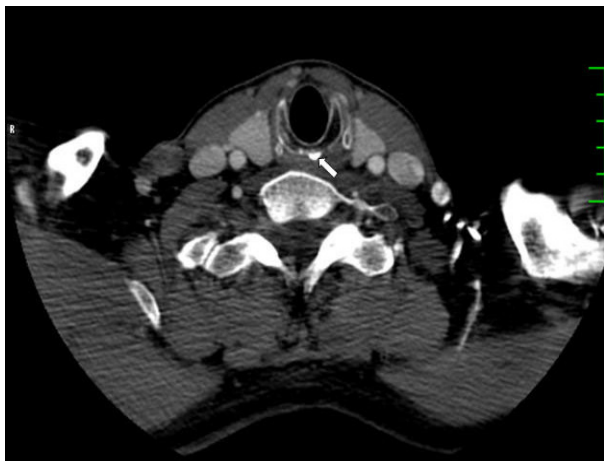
Axial CT scan showing osteophyte arising from the cricoid cartilage (white arrow).
